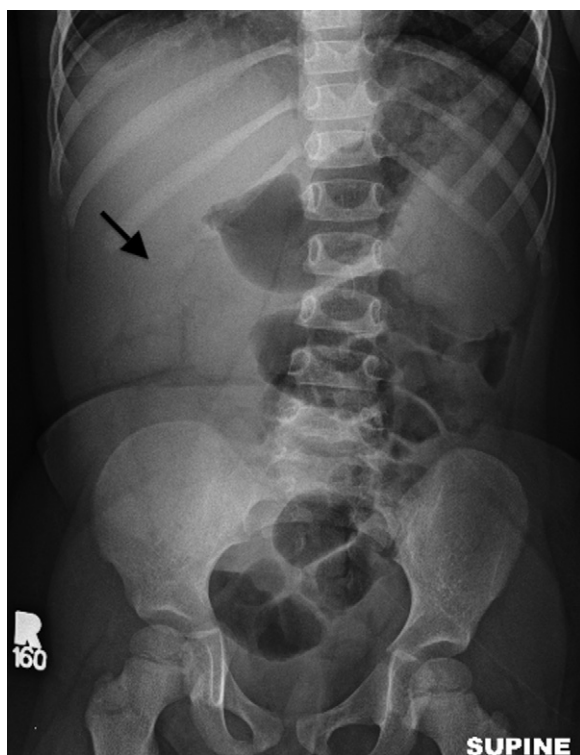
Plain radiograph of the abdomen with nonspecific findings suggestive of a right-sided soft tissue mass (arrow) combined with an absence of cecal gas.
